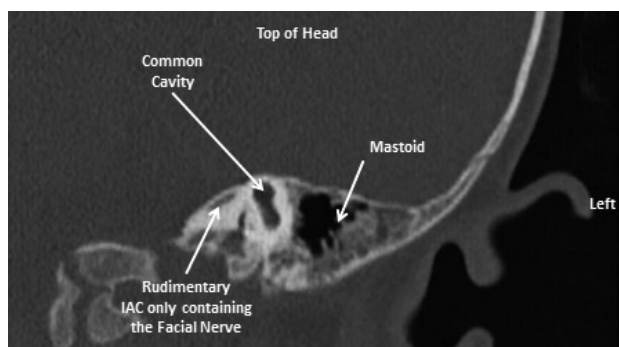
Coronal CT image of the left temporal bone showing a common cavity not connected to the narrow internal auditory canal (IAC). The IAC was only continuous with the facial nerve.
